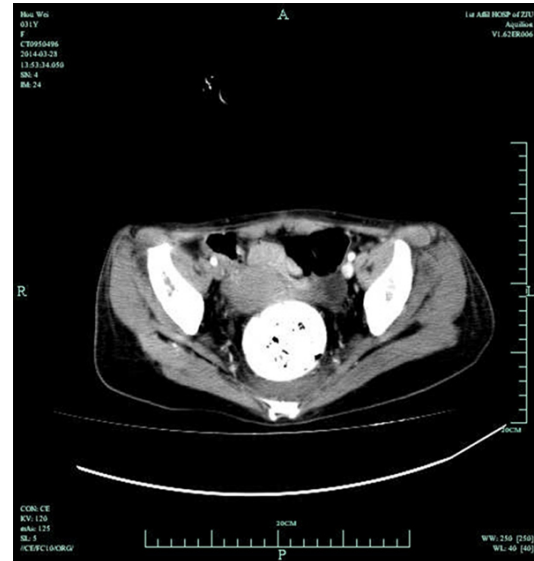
Abdominal contrast-enhanced CT scan showed the presence of a cyst in the left ovary, considering physiological cyst.
